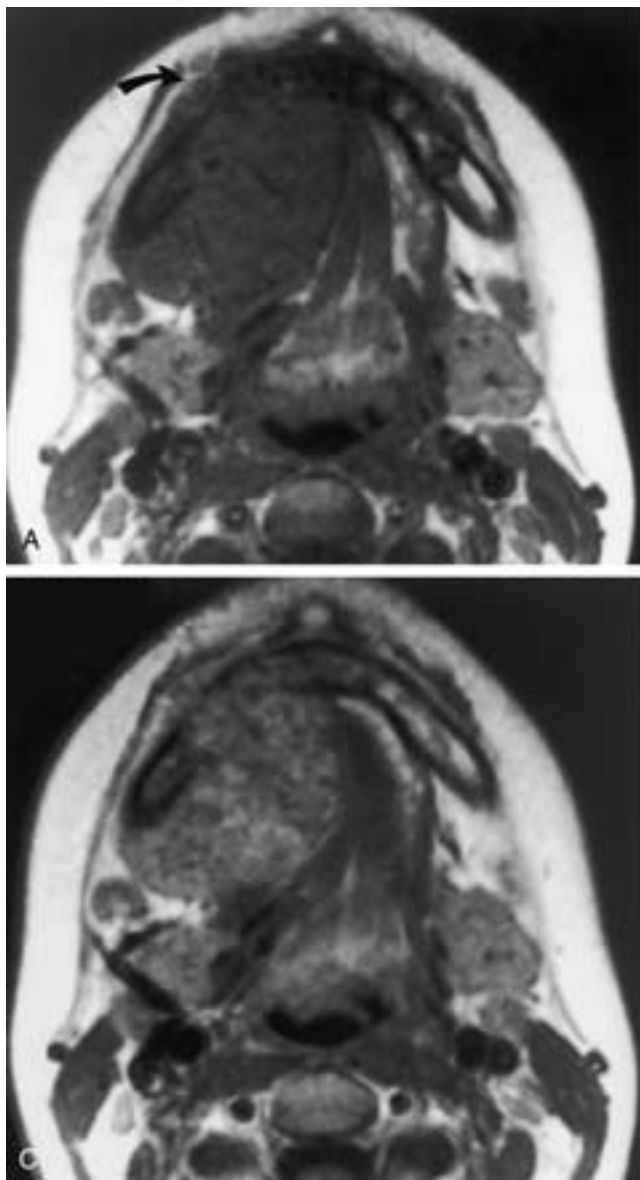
Giant cell tumor. (A) Proton density and (B) T2-weighted axial MR images demonstrate a large, heterogeneous, well-defined lesion that appears to have its epicenter in the anterior floor of the mouth or alveolar ridge on the right. The lesion is isointense to muscle on the T1-weighted image (A) and becomes progressively more hyperintense on the more heavily T2-weighted image (B). The lesion has extended to erode a large portion of the lingual surface of the right mandible and break through into the soft tissues on the buccal surface of the mandible (arrows). C, Following the administration of contrast, very heterogeneous mild enhancement is identified. Although in some respects this lesion may be difficult to differentiate from squamous cell carcinoma, the very clear, well-defined margins and the high signal intensity on the T2-weighted image mitigate against this diagnosis. (Courtesy of Dr. Jan Casselman.)
